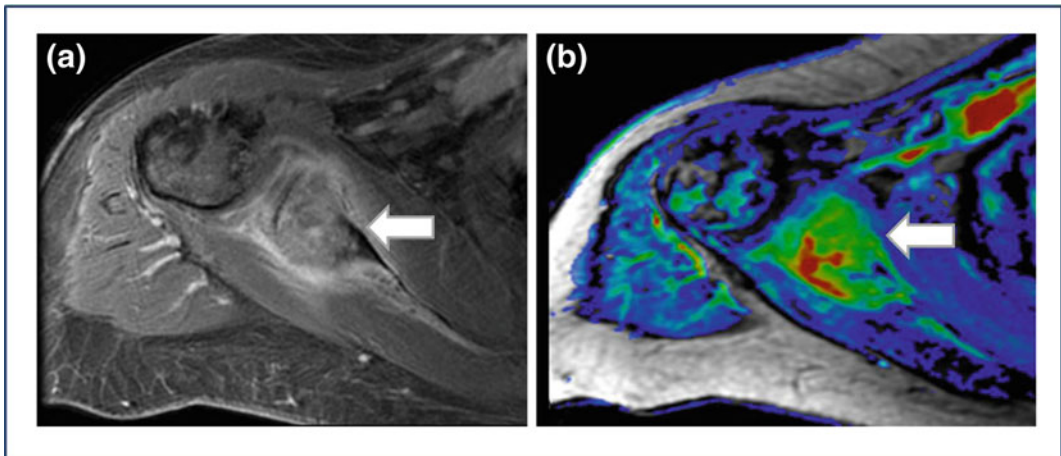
a T1-weighted GRE fat-suppressed, dynamic contrast-enhanced, axial image of a painful metastatic lesion on right scapula. b Color map expressing K_{trans} function for the same lesion, assessing a quantitative perfusional study
